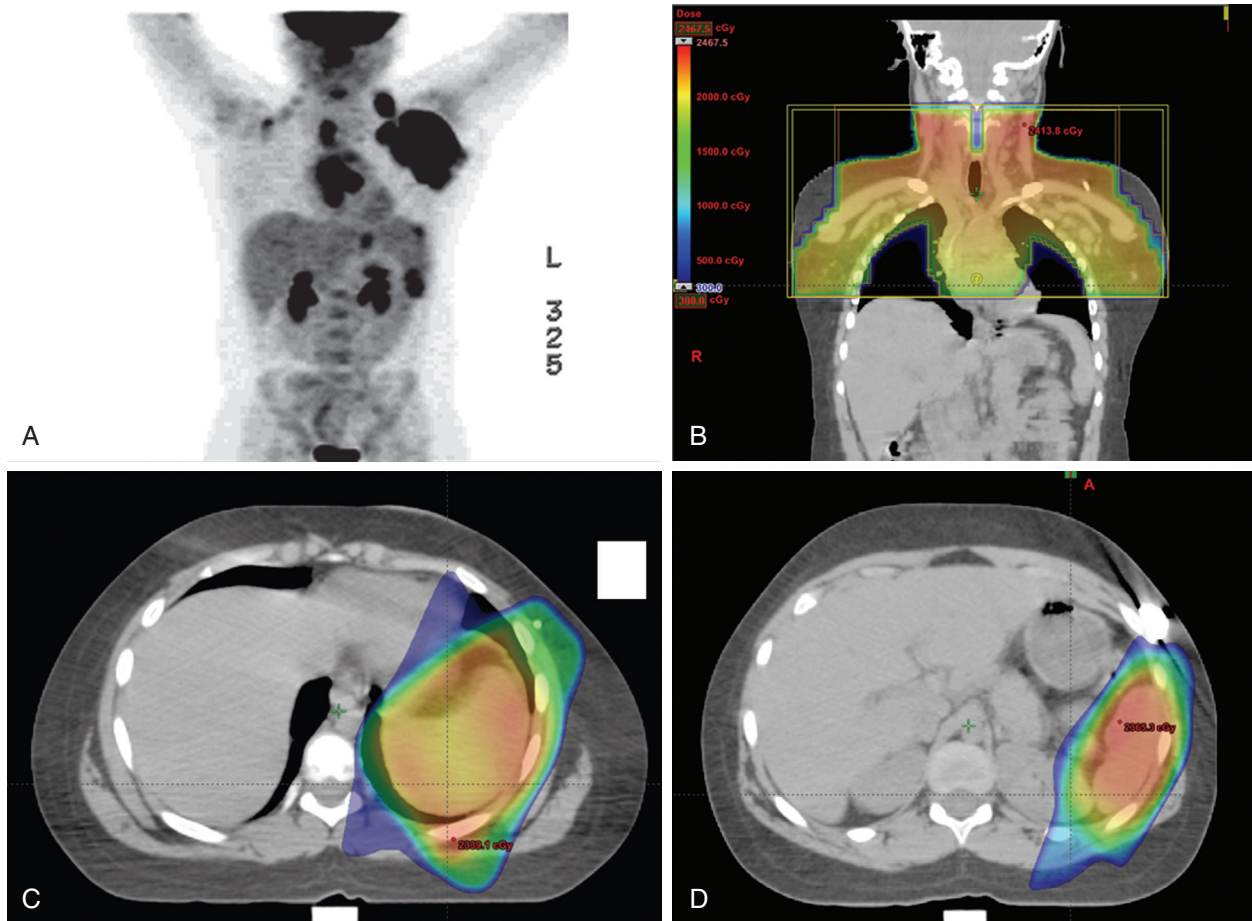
Use of non-standard IMRT to treat spleen along with anteroposterior and posteroanterior (AP-PA) mantle field. A 12-year old presented with stage IIAS lymphocyte predominant Hodgkin's lymphoma with bulky right axillary adenopathy. On staging evaluation, PET scanning shown in Panel A showed bilateral neck and axillary adenopathy, bulky mediastinal disease, as well as multiple splenic nodules. After a complete response to ABVE-PC chemotherapy for four cycles, involved field radiotherapy to 21 Gy in 14 fractions was initiated. The supradiaphragmatic disease was well covered by standard APPA fields as shown in Panel B. APPA or oblique fields to the spleen would have treated too large a volume of the heart or kidney. Instead, a four-field IMRT field along with shallow breathing and appropriate margin for respiratory motion was devised. Panel C and D show superior and inferior aspects of the spleen treatment with the dose distribution shown with a color wash superimposed on the treatment planning CT scan. IMRT technique successfully minimized dose to the heart and left kidney.
